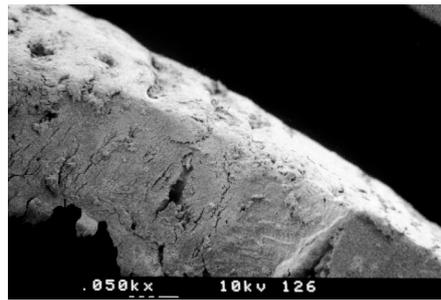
SEM analysis of ultrasonic implant site preparation. Bone surfaces appeared slightly roughened by piezoelectric preparation. No smear layer, bone fragments or biologic material were seen over bone walls, and the bone vascular canals appeared clean and open, including the haversian canals and the few small medullary spaces of the cortical bone.
